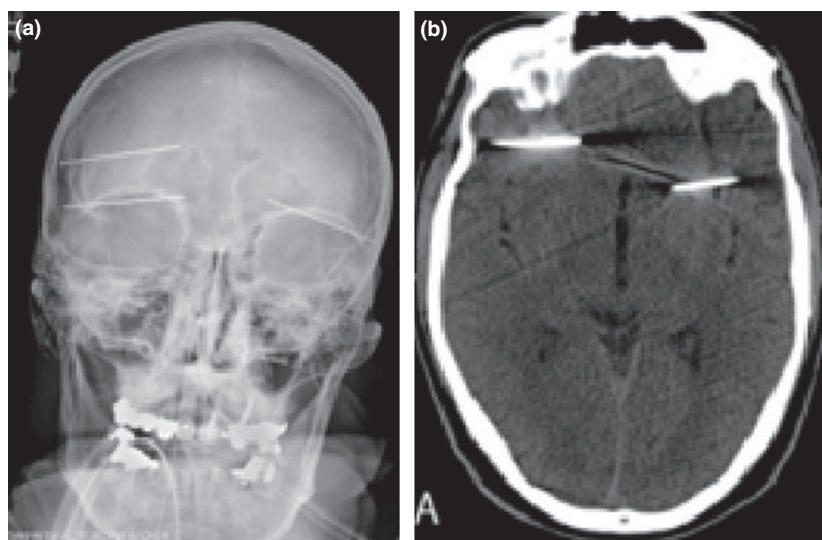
(a) AP skull radiograph showing three metal nails. (b) Axial non-contrast CT of the same patient. Note the metallic artefact.³²
